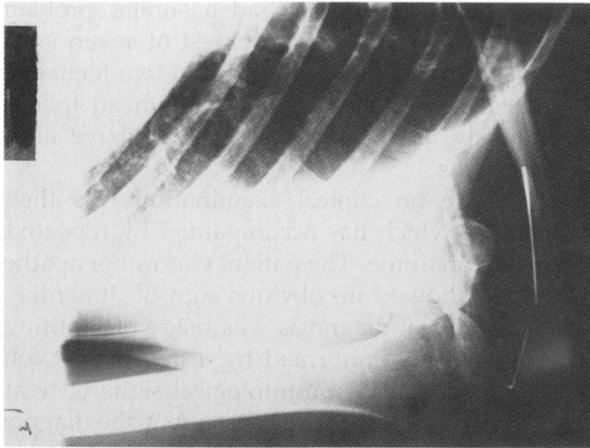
X-ray showing a fragmented Kirschner Wire
